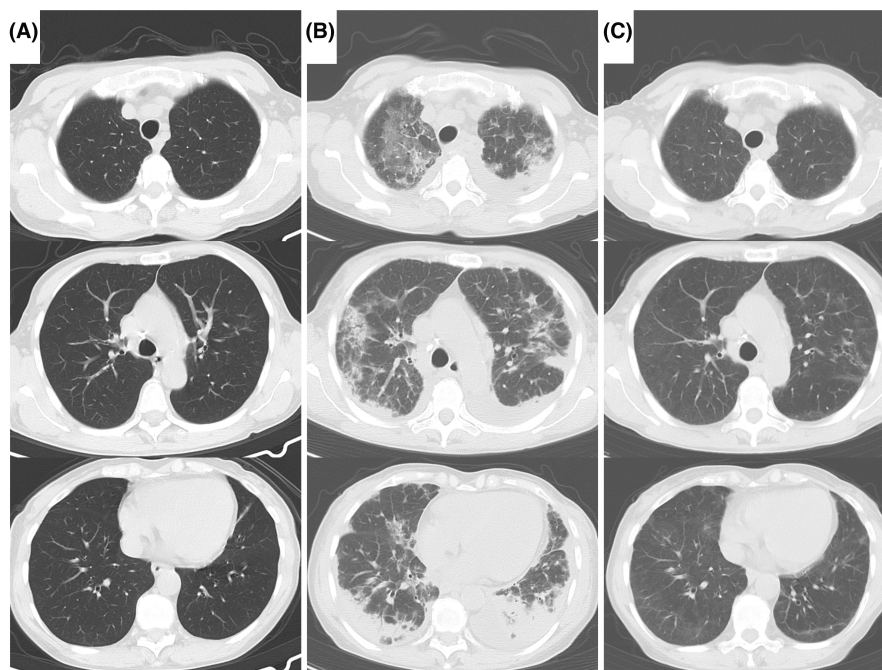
(A) Chest CT with no pulmonary lesions on admission. (B) Chest CT showing bilateral multiple ground-glass opacities, consolidation, and small bilateral pleural effusions 2 months after venlafaxine treatment. (C) Chest CT revealing remarkable improvement 3 months after discontinuation of venlafaxine and corticosteroid treatment. Regarding corticosteroid administration, 500 mg methylprednisolone was first administered for 3 days, then tapered to 40 mg/day prednisolone and then discontinued over 3 months. A probable relationship between venlafaxine and interstitial lung disease was obtained with an Adverse Drug Reaction Probability Score (Naranjo nomogram) of 7. Abbreviation: CT, computed tomography
